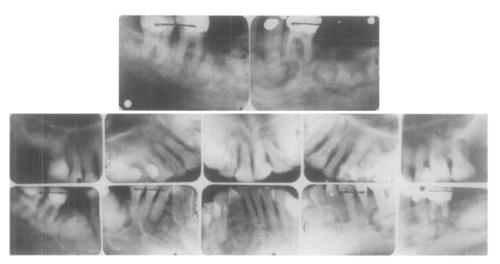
Above: Periapical radiographs of the mandibular molar regions taken in 1935, showing the presence of multiple separate areas of radiopacity. Below: Complete mouth radiographs taken in 1941, showing the presence of radiopaque areas in relation to the roots of mandibular teeth.
